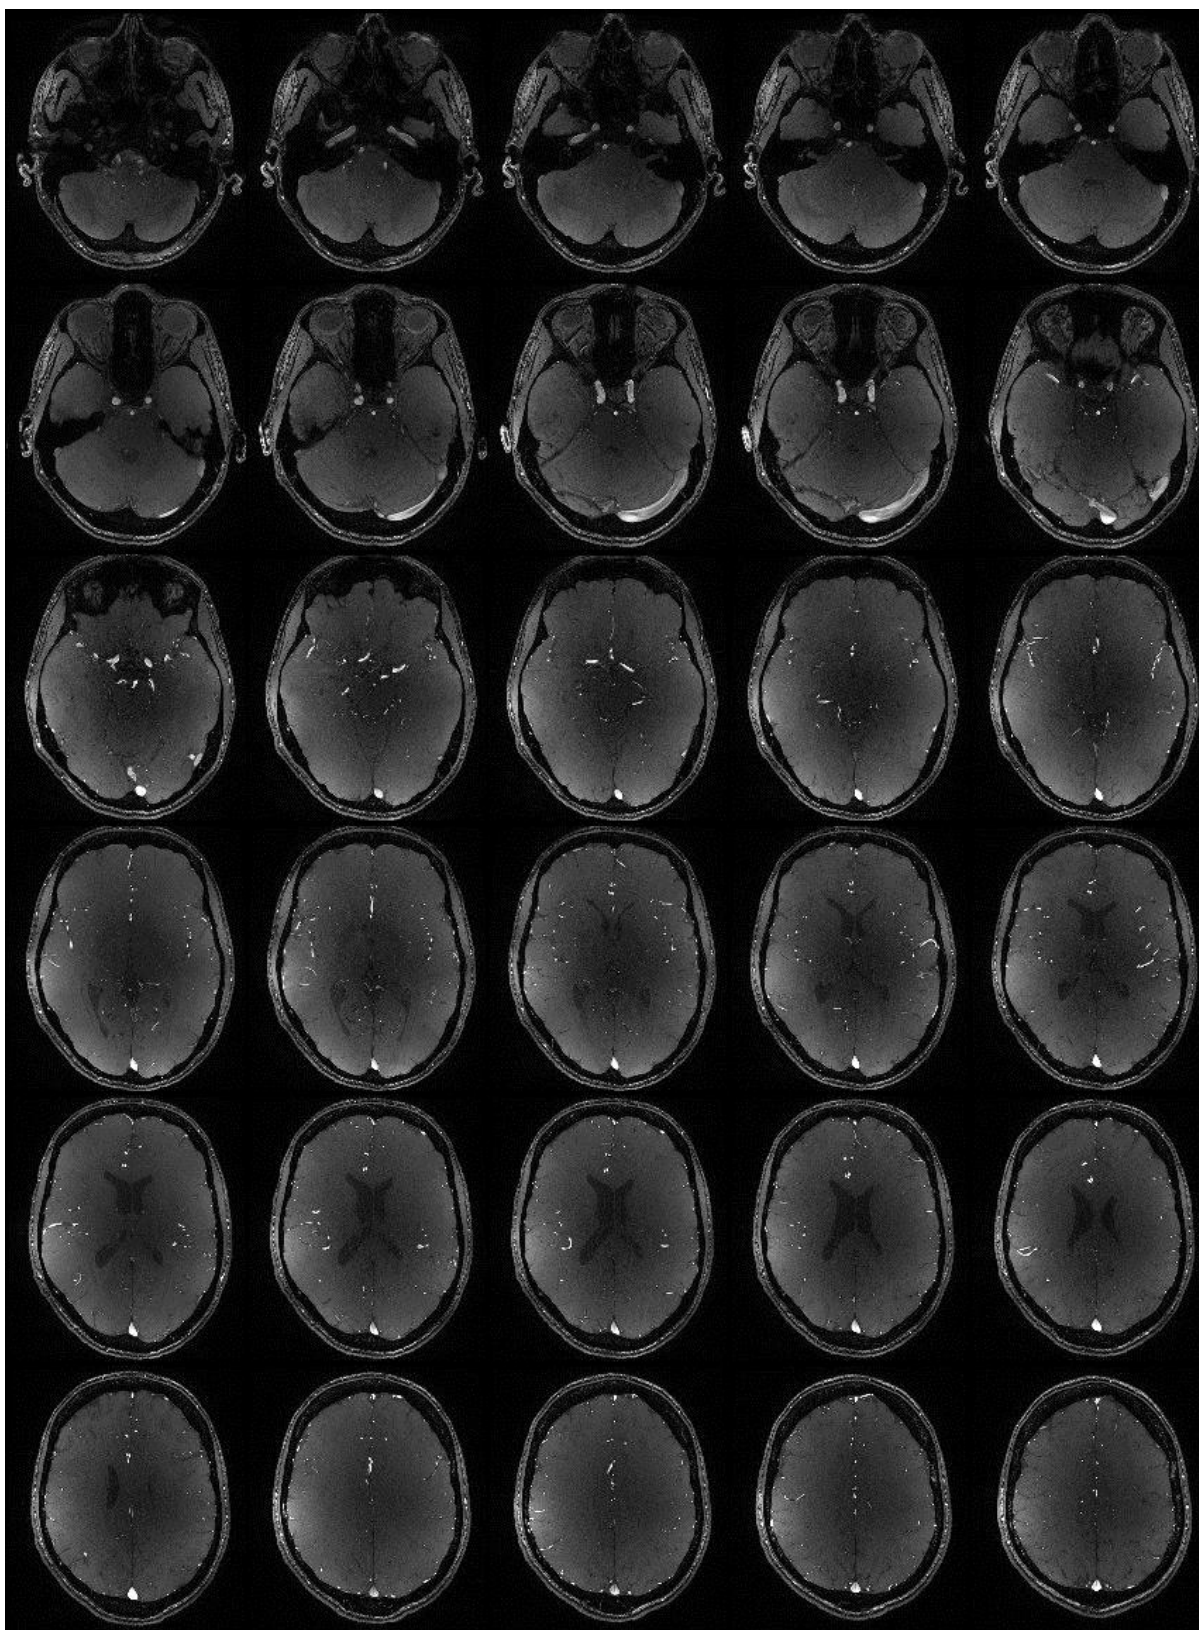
Figure B-2. MRI montage image of normal subject 2
